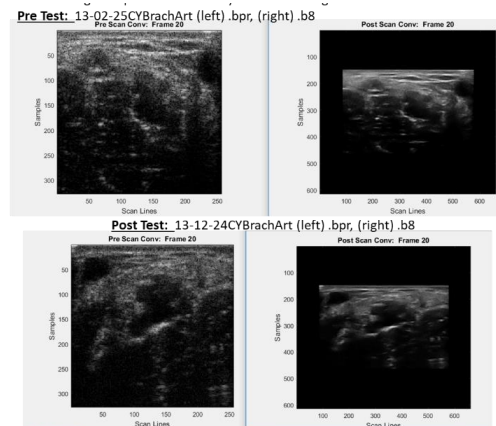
B mode images acquired concurrently with color Doppler mode images. Left side images are pre scan converted images. Right side images are scan converted images. (top row) baseline, and (bottom row) after physical exertion.
